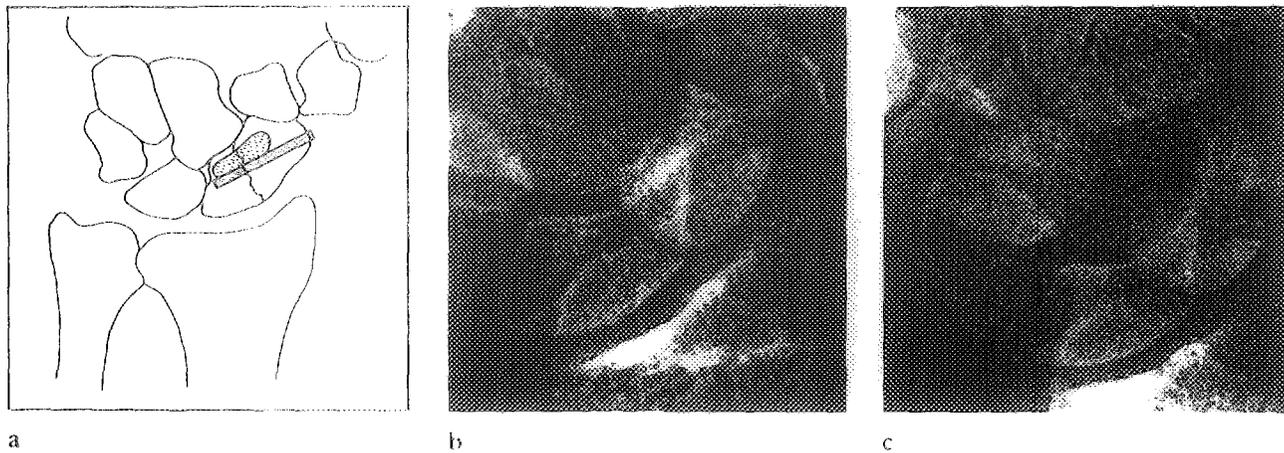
Fixation and bone grafting for delayed union of the scaphoid bone (a). Radiograph of non-union of a fracture of the scaphoid bone seen before surgical intervention six months after trauma (b) and as healed one year after fixation with one 2 by 25 mm BIOFIX®-rod and bone grafting (c)
